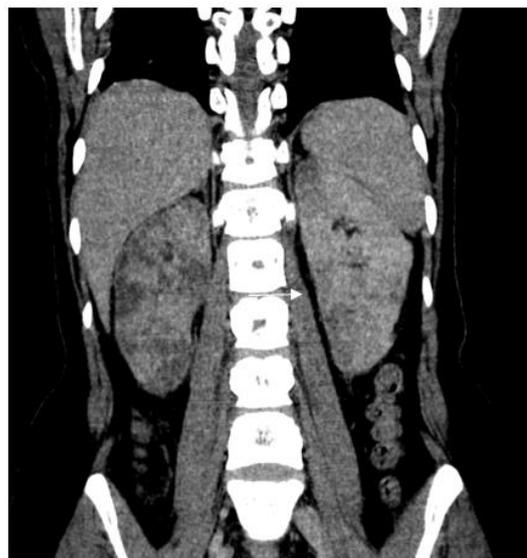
Contrast-enhanced abdominal CT scan (coronal) showing multiple renal hypodense areas of triangular shape and peripheral base, surrounded by a rim of subcapsular enhancement parallel to the renal margin (arrow) (the cortical rim sign)
